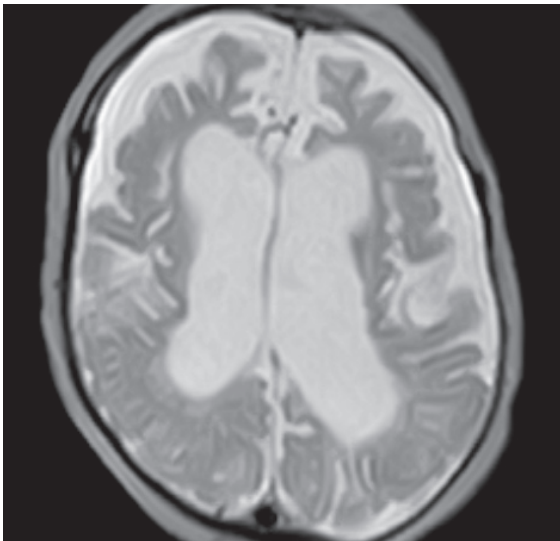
Brain magnetic resonance imaging. Control brain MRI (at 4 months of age) demonstrating decreased cerebral parenchyma volume, the expense of WM, with gliosis zones and dilated ventricular system and cerebellar hemisphere hypoplasia with partial vermis agenesis.
